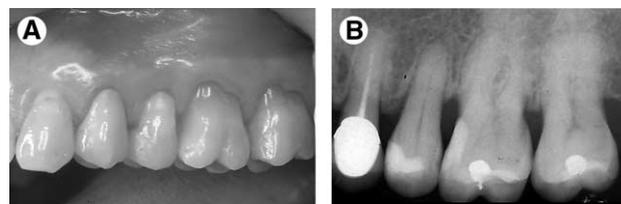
Posttreatment photographs. (A) Left buccal. (B) Periapical x-ray.
